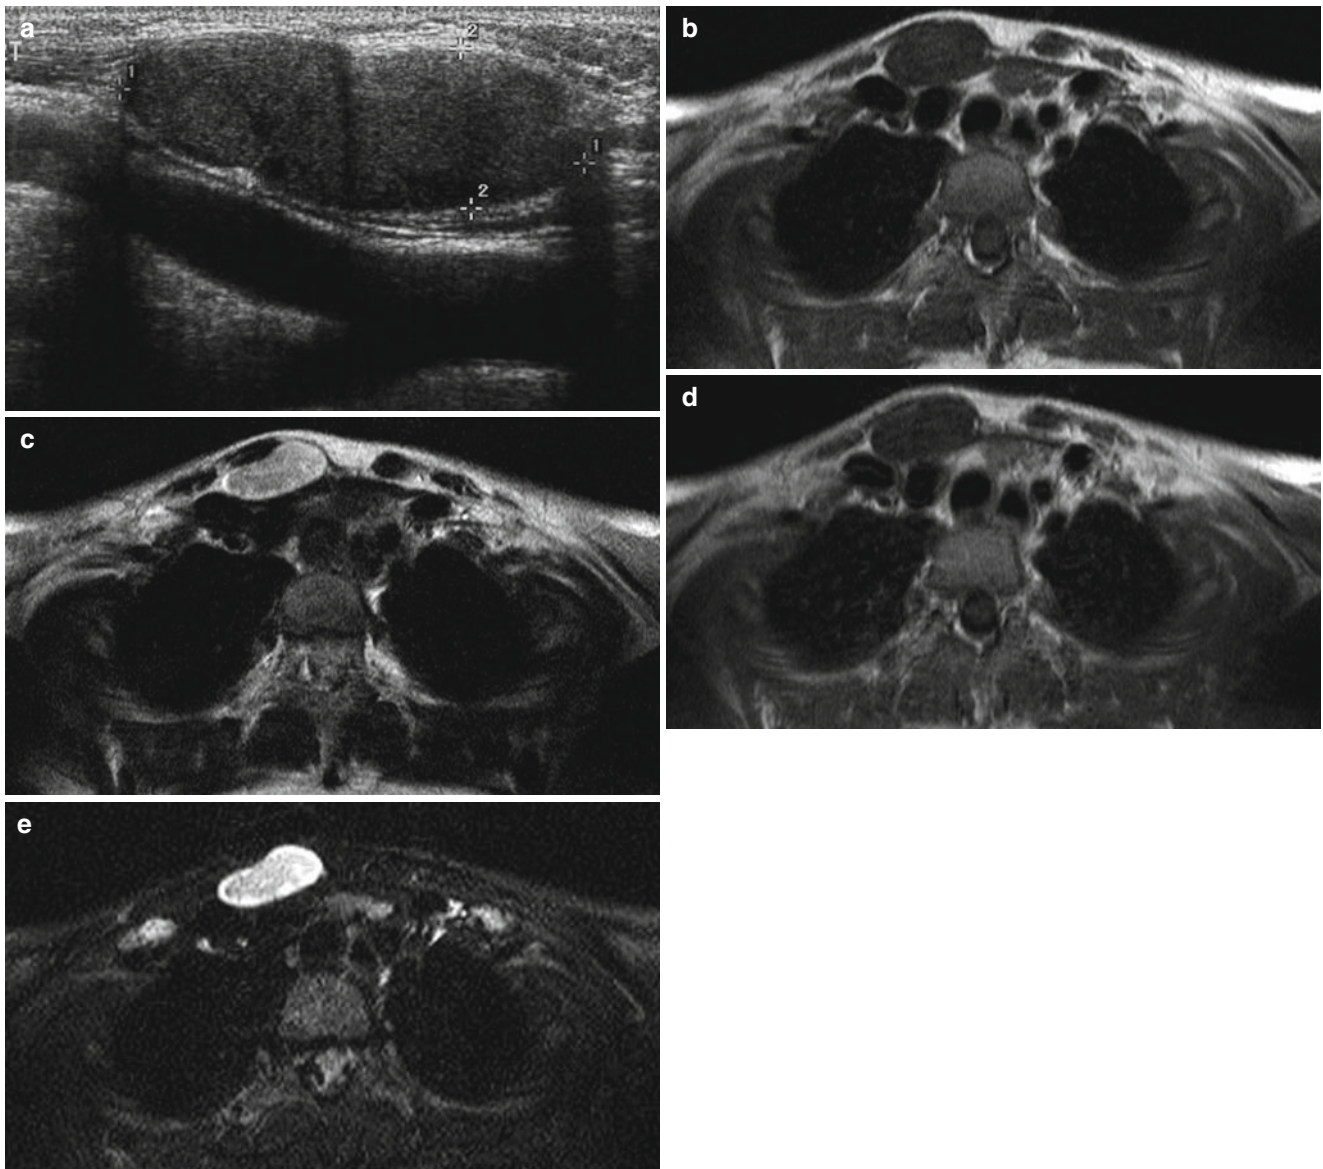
Epidermoid cyst in a 10-year-old girl. (a) US shows a bilobed hypoechoic lesion in the region of the right sternoclavicular junction. Note the internal echogenic foci. (b–d) The mass appears as isosignal intensity on T1-weighted image (b) and slightly high signal intensity on
